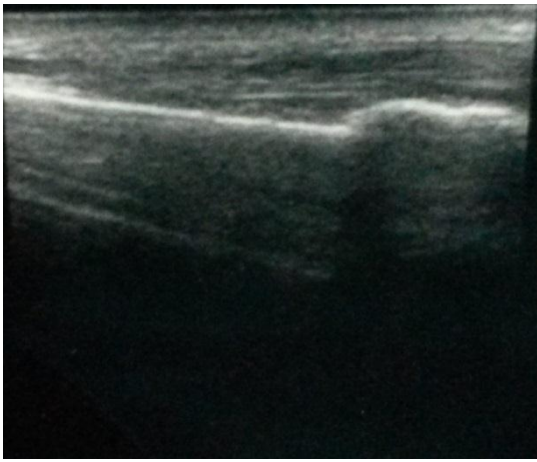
a : showing ultrasonic picture of distal radial fracture
